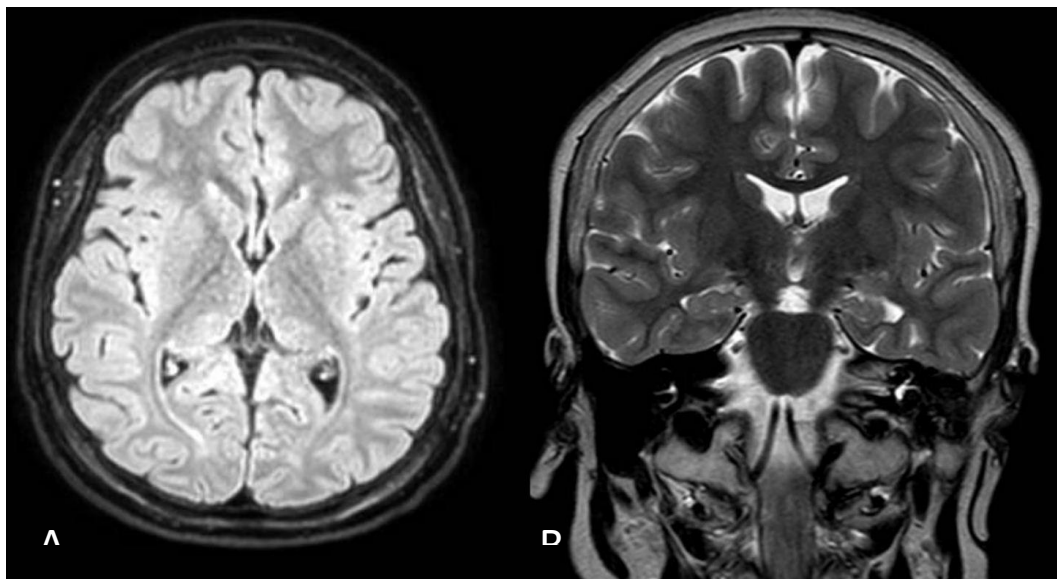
(A) Brain MRI, including axial FLAIR and (B) coronal T2-weighted sequences, reveals no significant structural abnormalities
